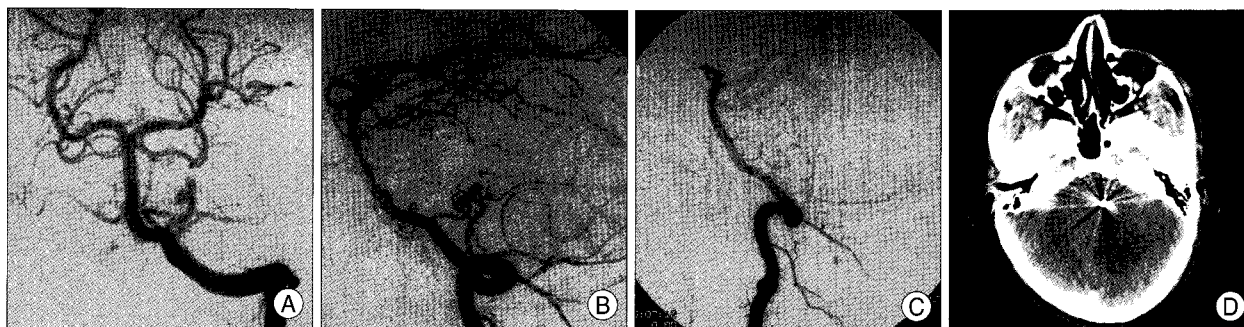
Case 7. A 27 year-old male presented with ruptured posterior inferior cerebellar artery (PICA) aneurysm in the lateral medullary segment. A and B : Anteroposterior and working projection view of left vertebral artery reveals the bilobulated saccular aneurysm in the left lateral medullary segment of PICA. C : Working projection view of left vertebral artery after Guglielmi detachable coil embolization shows main PICA trunk occlusion with no contrast filling of aneurysm sac. D : Brain computed tomography reveals low density in left cerebellum correlating with PICA territory four day after coil embolization. However, the patient had no neurological deficit but mild headache after detachable coil embolization.
